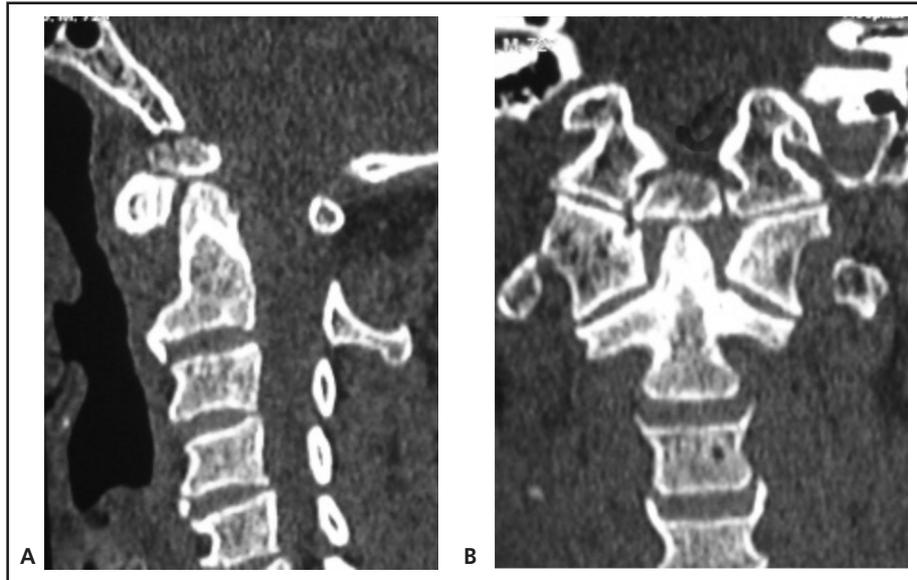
Sagittal CT Cervical showed an anomalous bone seen between the anterior arch of the atlas and the occiput. The dens is relatively short but retains its normal contour (A). Coronal view showed anomaly formation of bone above the dens of C2. CT appearance is consistent with the presence of a median condyle (B).
